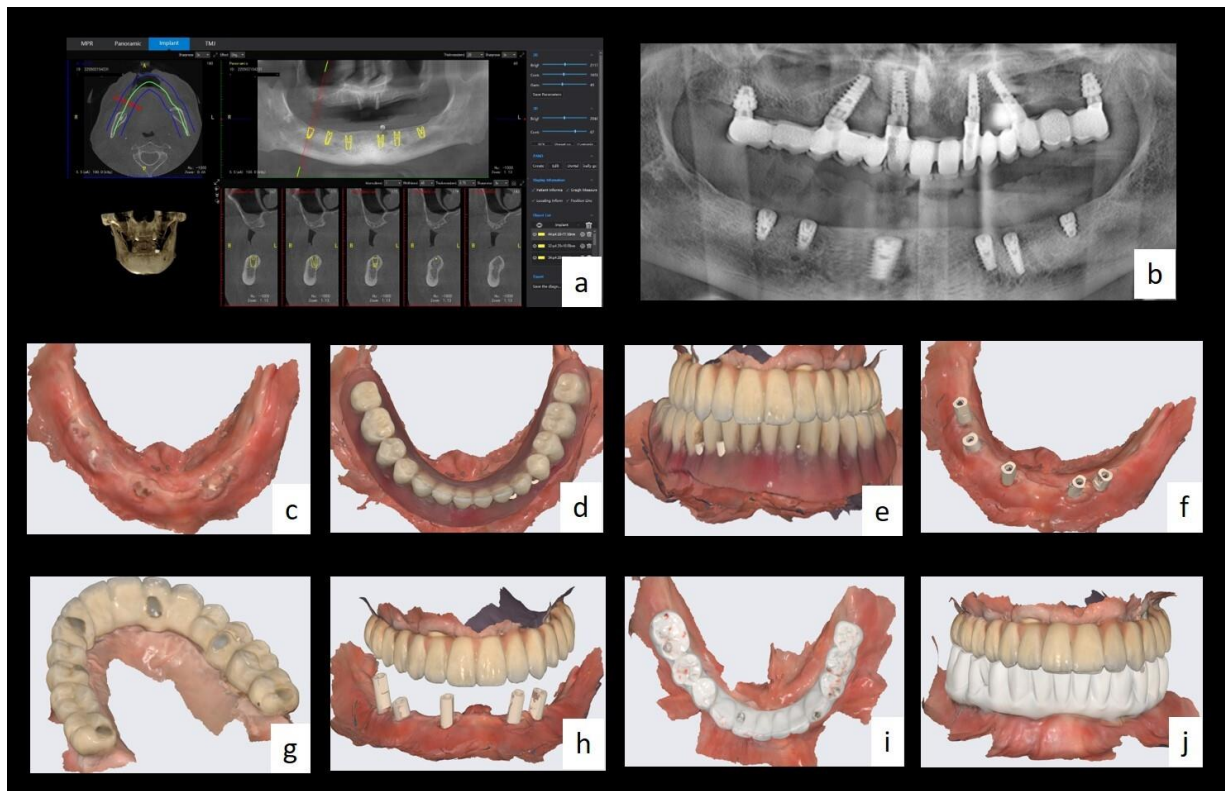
a) CBCT planification of the mandibular implants positioning. b) OPG made to assess the mandibular implants bone integration. c) Edentulous mandible scan. d), e) Lower removable denture scan to send to the dental lab, to keep the data about the teeth (shape, size) and occlusion. f) Scan bodies. g) Maxillary implant-supported porcelain fused to metal restoration scan. h) Intermaxillary relation (centric occlusion). i) Try-in intraoral scan showing articulating paper marks. j) Intermaxillary relation.
